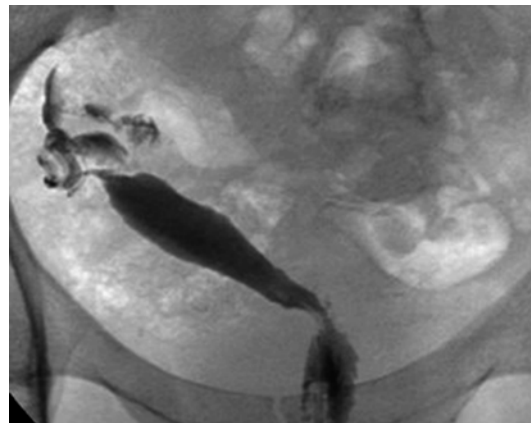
Right hemi-uterus. HSG suggested a right unicornuate /hemi uterus, ultrasound confirmed that this represented an isolated system with no rudimentary horn and the presence of a single right kidney U4b C0 V0
